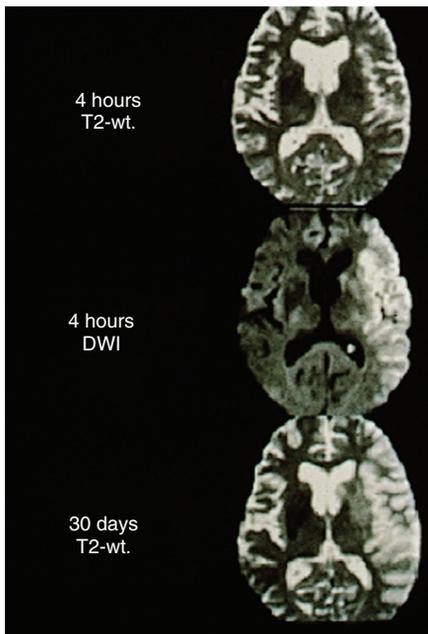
Magnetic resonance imaging (MRI) showing possible advantages of diffusion-weighted imaging (DWI) relative to conventional MRI at early times after vascular occlusion. *Top*, Conventional T2-weighted MRI 4 hours after symptom onset that appears normal. *Middle*, At the same time, a DWI scan shows abnormalities in the left hemisphere. *Bottom*, Repeat T2-weighted MRI 1 month later showed an infarction in the same location as the initial DWI scan. (Courtesy of Gregory W. Albers, Stanford University, Stanford, Calif.)
